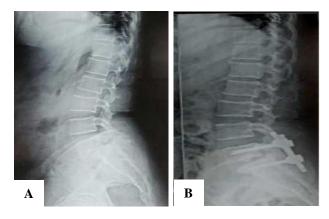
(A, B): Pre-operative and post-operative x-rays.
